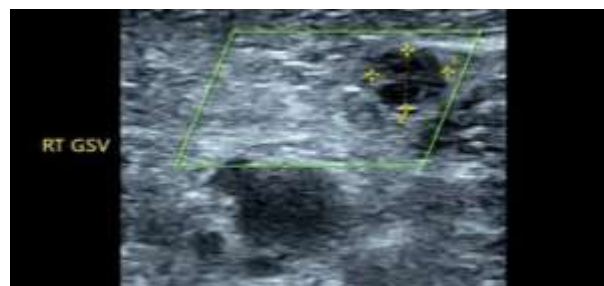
Doppler ultrasonography of the right lower limb showing non-compressible, echogenic thrombus within the right great saphenous vein (RTGSV), confirming deep vein thrombosis.
